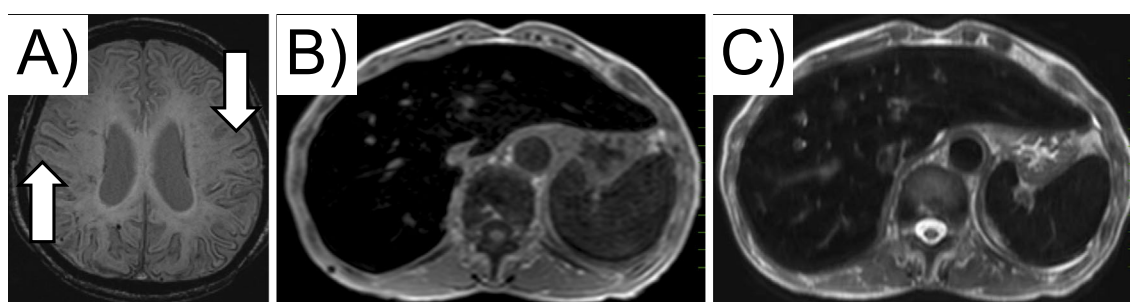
Brain and abdominal magnetic resonance imaging. A) Susceptibility-weighted magnetic resonance imaging showed a marked hypointense signal on the surface of the brain (arrows), which coincided with superficial hemosiderosis of the central nervous system. The liver showed slight swelling with low density on T1-weighted images (B) and T2-weighted images (C).
